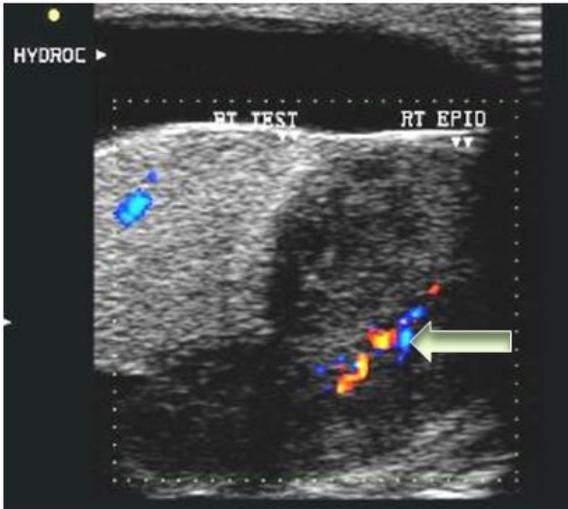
b: Colour Doppler shows increase in vascularity (Colour Doppler Image)
